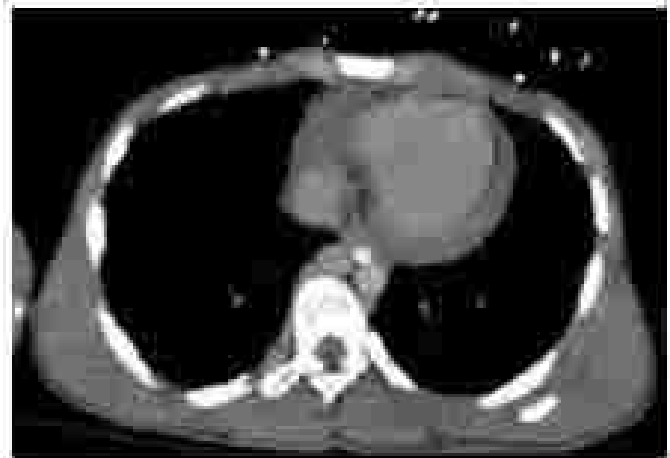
Chest computed tomography scan of the chest in a young man with a grade 4 blunt cardiac injury demonstrating a pericardial effusion.
